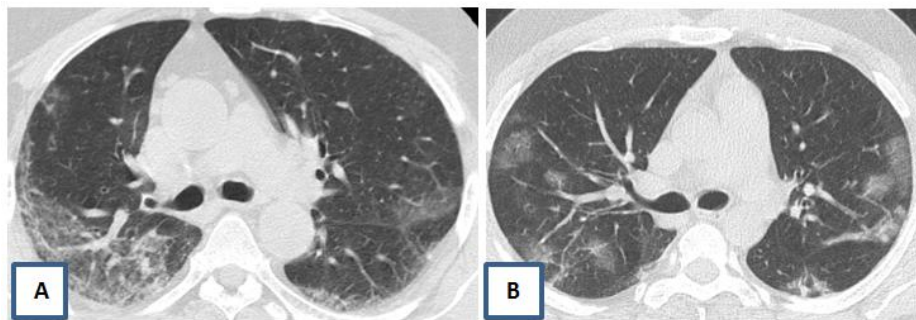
Chest CT with axial plane showing: A - Patchy ground-glass opacities in the bilateral lower lung lobes. B - Minimal nodular ground-glass opacities in the bilateral lower lung lobes
